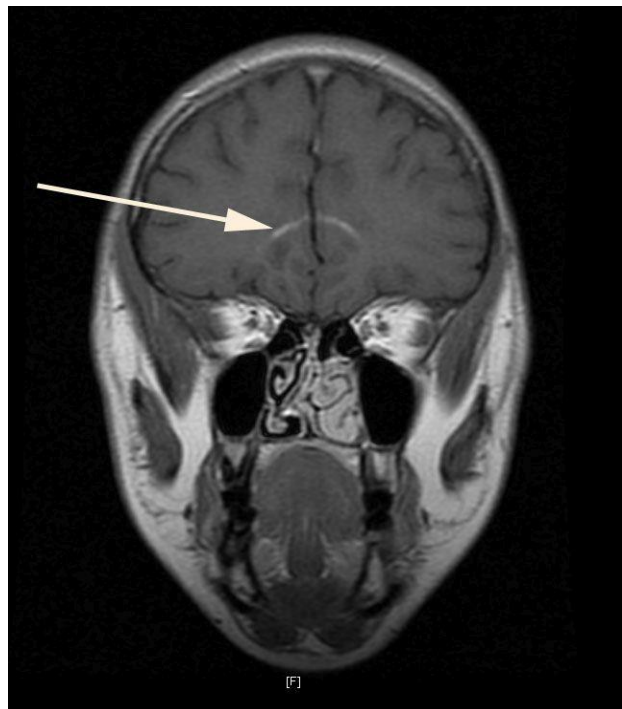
MRI coronal section with gadolinium contrast showing marginal enhancement of the demyelinating lesions (arrow).
